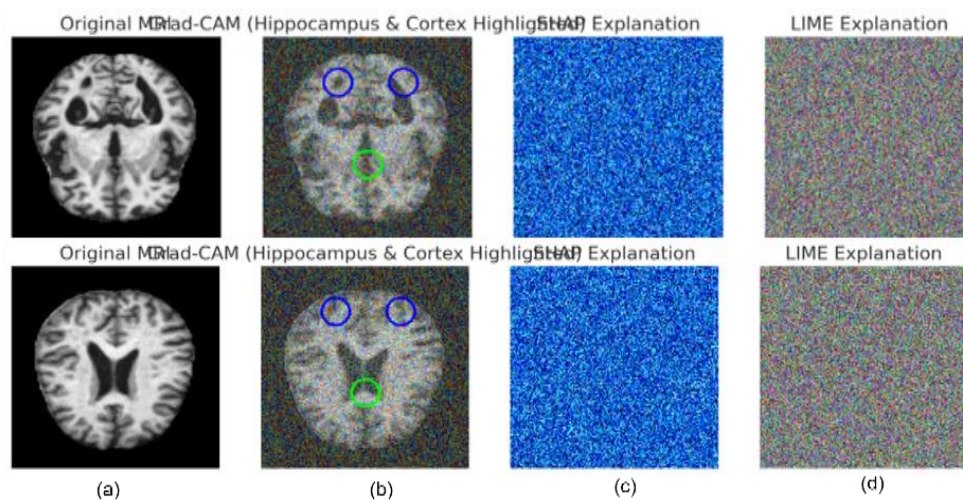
Represents identification of key biomarkers for early-stage AD prediction: (a) original MRI Scan, (b) Grad-CAM (Hippocampus, Cortical Regions), (c) SHAP, and (d) LIME
